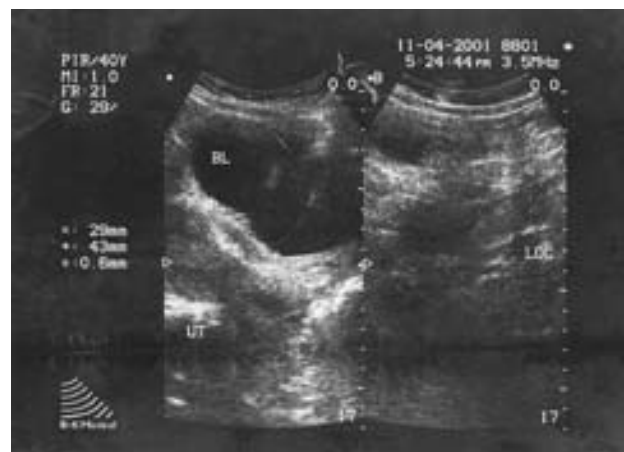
Premenstrual transabdominal median longitudinal ultrasound scan of pelvis. The bladder has normal appearance.
